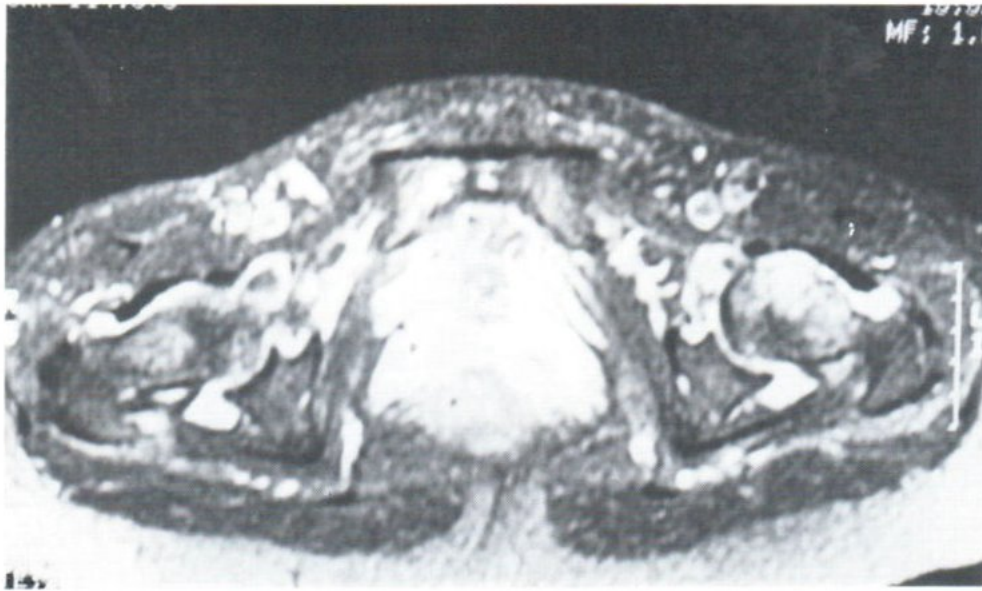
T1-weighted fat-suppression enhanced axial MR image reveals that the proliferated synovium and the edematous marrow show inhomogeneous enhancement
